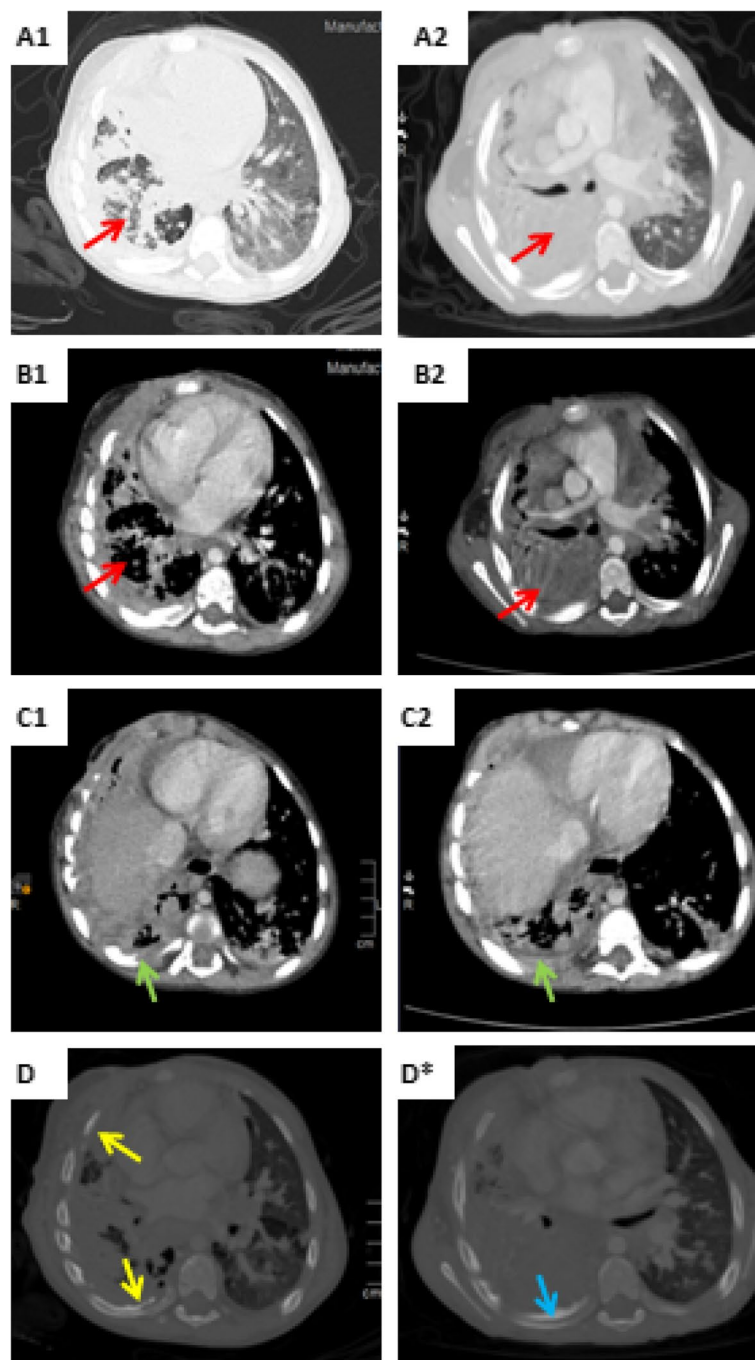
Chest CT scans three months apart. (A1, A2), (B1, B2), and (C1, C2): enhanced chest CT scans at a 3-month interval in the parenchymal (A) and mediastinal (B, C) windows, showing a reduction in parenchymal consolidation (red arrows) with a decrease in the right lung volume. The disappearance of the small right pleural effusion was also noticed (green arrow). D, D* Chest CT scan in bone reconstruction showing bone lesions of the anterior and posterior costal arches: lytic bone lesions with cortical thickening (D, yellow arrow), periosteal reaction (D*, blue arrow)
